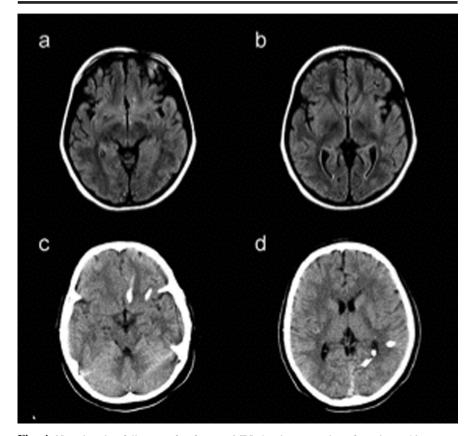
Neuroimaging follow-up after 3 years. MRI showing regression of previous white matter abnormalities in the left frontal (a) and temporal lobes (b) (axial FLAIR). CT scan showing juxta-cortical and subependymal calcifications, at the left frontal (c) and temporal (d) lobes, at the same sites where the MRI lesions had been previously visualized.
